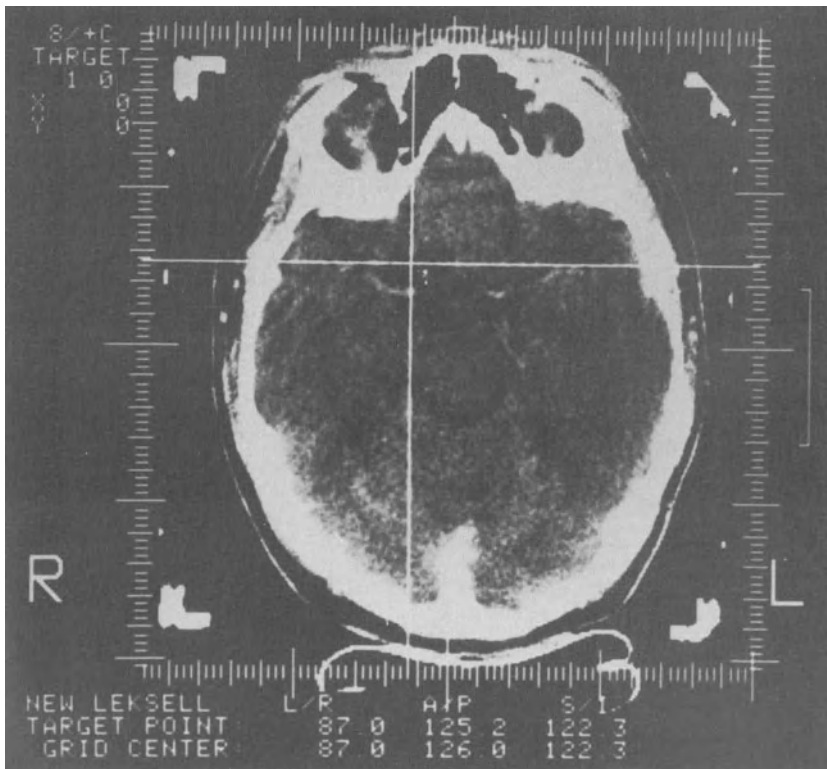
A grid can be displayed over the CT image containing the target by means of a special software package. The coordinates can be read directly.
